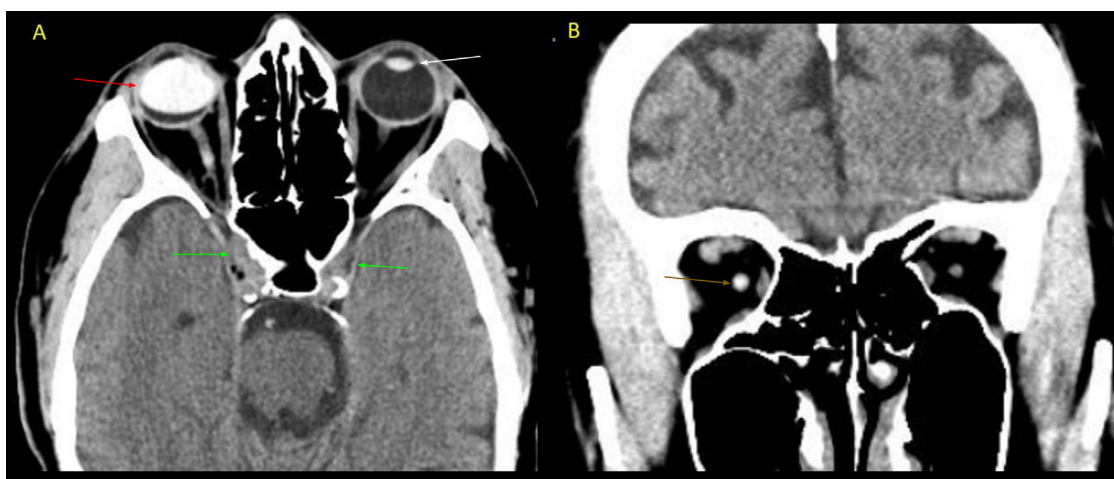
CT angiogram of the head following transfer to the neuro ICU. CT angiogram images with an axial view (A) and coronal view (B). Images show high-density silicone, red arrow, in the right ocular vitreous cavity related to prior silicone oil injection for treatment of retinal detachment. There is also migrated silicone in the intraorbital segment of the right optic nerve. The brown arrow demonstrates the optic nerve. The white arrow represents the lens. The green arrows point to the cavernous sinus.
